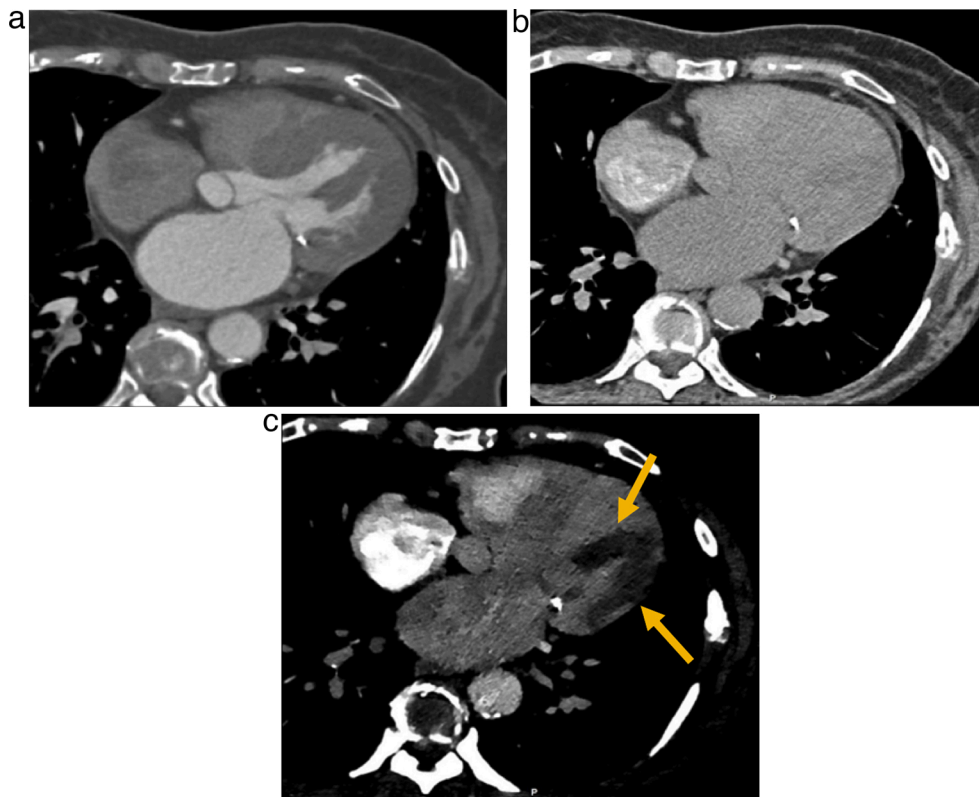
Assessment of myocardial perfusion on DECT. A 81-year-old woman with history of chronic atrial fibrillation was planned for a left atrial appendage occlusion procedure. A planning cardiac CT; Early (a) and delayed conventional CT images (b) were unremarkable, however there was a clear large perfusion defect (Arrows), consistent with infarction, seen involving lateral left ventricular myocardium and papillary muscle on low keV VM image from delayed scan (c). Subsequent cardiac catheterization revealed total occlusion of the first obtuse marginal branch of the left circumflex coronary artery (not shown).
